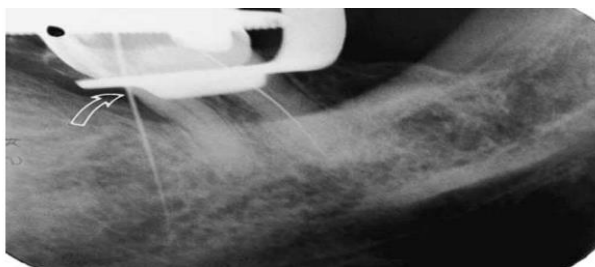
Placing a file in a site of suspected perforation (arrow) and taking a radiograph will show the position of the file in relation to the root. Note that in this tipped molar, the distal canal has been properly located, but the mesial orifices were missed.
